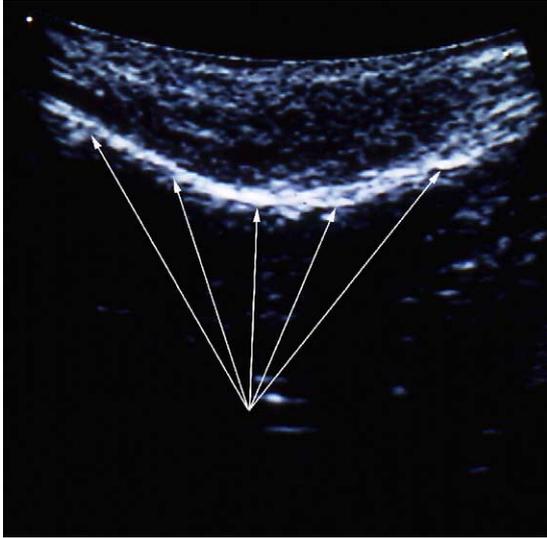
Ultrasound image of the normal anatomy of the medial orbital wall. The arrows show the convex structure of the medial orbital wall. Compared to the lateral orbital wall the medial wall shows more convexity.
